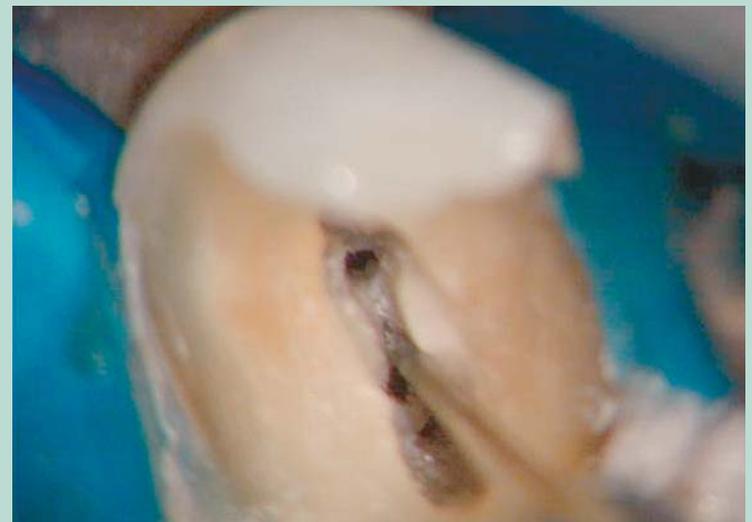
A Carr 'Slim-Jim' ultrasonic tip at low power is used to remove the tissue from the isthmus
